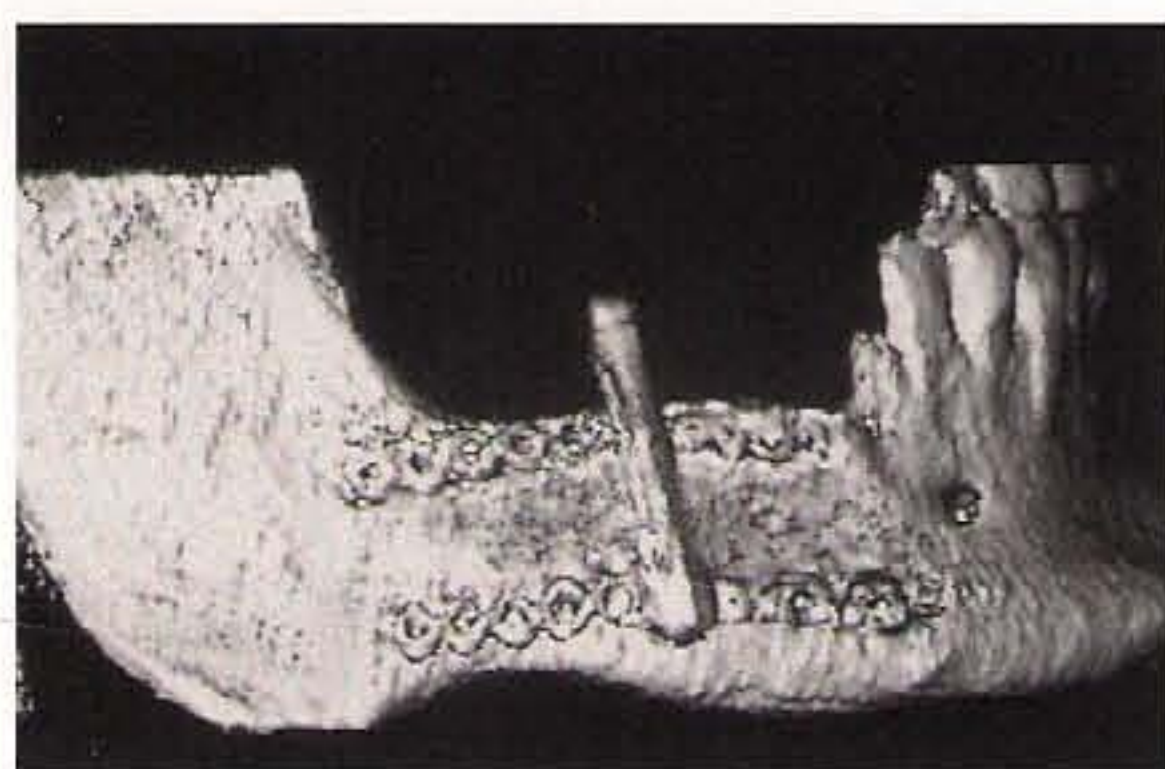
In a CT scan made 3 months after distraction, the 8-mm vertical augmentation of the crest is visible.
